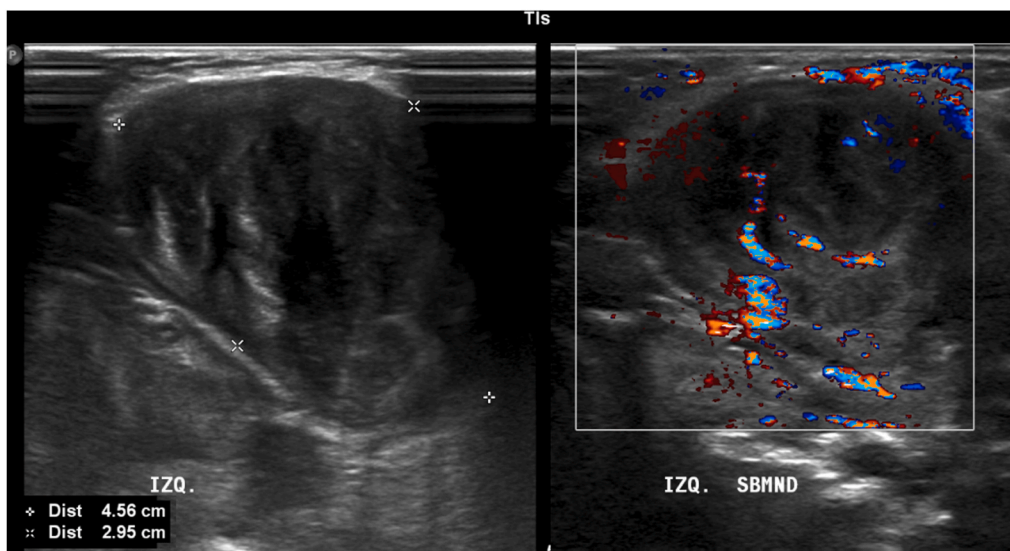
Ultrasound features of the initial submandibular lesion.
